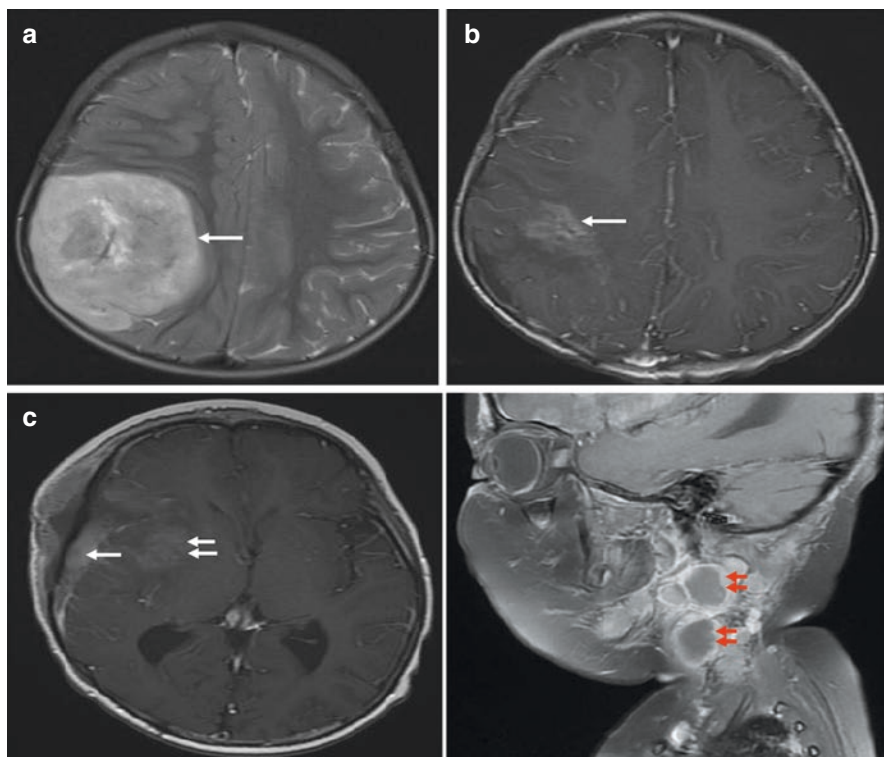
MR images of a patient with C19MC-altered ETMR, ETANTR subtype including (a) initial MRI of the brain with contrast showing enhancing lesion in the right parietal lobe (*arrow*), (b) MRI brain at 10 months after initial surgery showing recurrence in the resected cavity (*arrow*), and (c) MRI brain and neck after 1 year of second surgery revealed local recurrence (*arrow*) with right temporal soft tissue enhancement (*white arrows*) with parotid gland and cervical lymph node involvement on the same side (*red arrows*)
